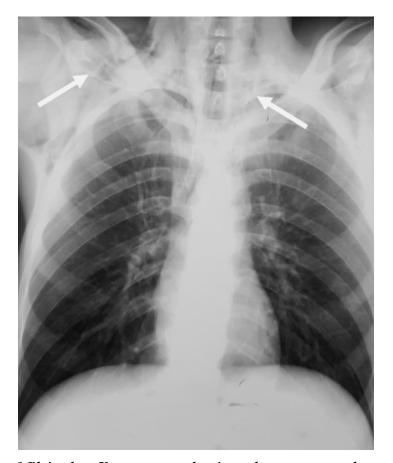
Plain chest X-ray: arrows showing subcutaneous emphysema
